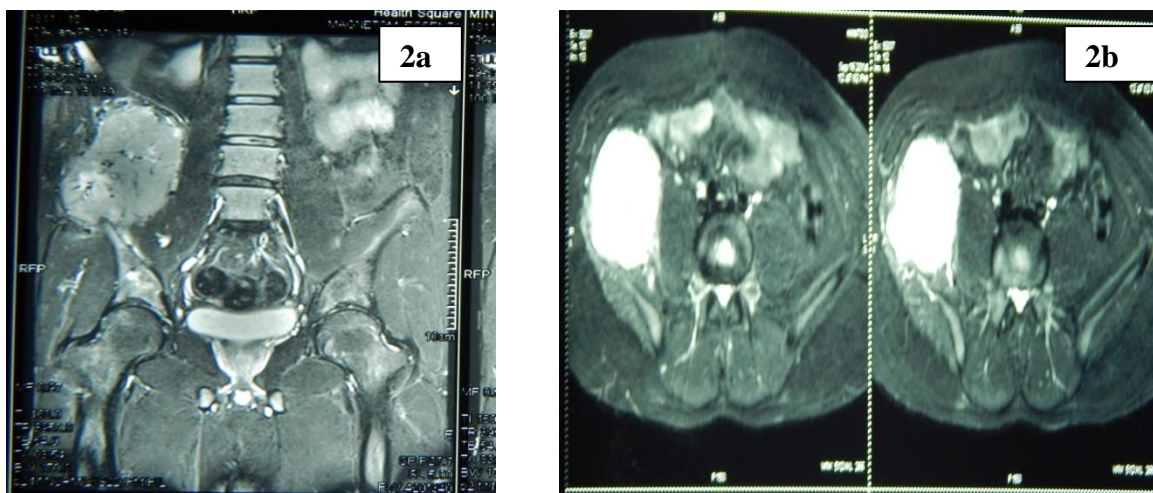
MRI Post contrast T1FS coronal image showing well defined homogenous enhancing soft tissue mass lesion in right iliac fossa involving right iliac bone and iliac crest with multiple small internal flow voids. 2b STIR axial image showing well defined STIR hyperintense signal soft tissue mass lesion in right iliac fossa involving right iliac bone and iliac crest involving right iliacus muscle. No evidence of calcification is noted
